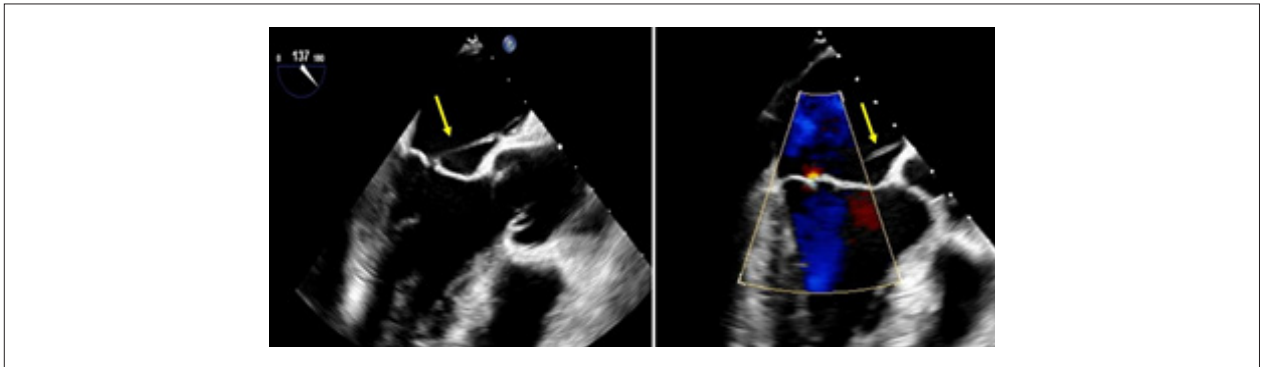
2D transesophageal echocardiogram images showing a fine, well-delineated structure (yellow arrow) originating from the interatrial septum to the tip of the anterior leaflet of the mitral valve. There is no significant regurgitation on the color Doppler (right).
